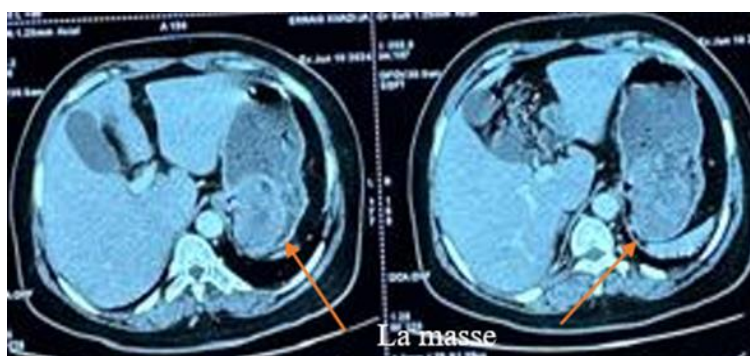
Computed tomography scan appearance of the mass
